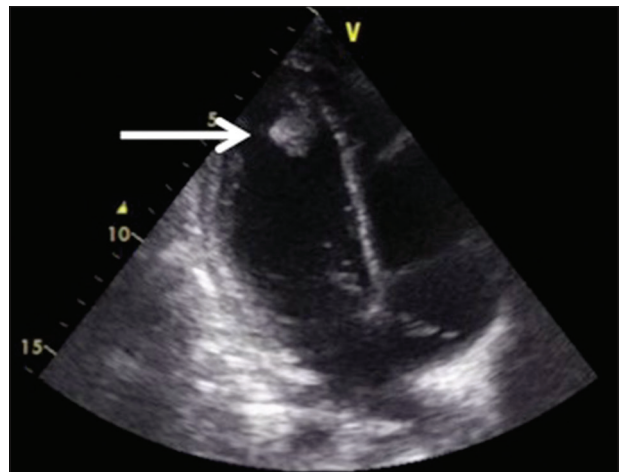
Two dimensional-Echocardiography showing 2.3 cm x 1.5 cm pedunculated mass within left ventricular cavity adherent to interventricular septum
